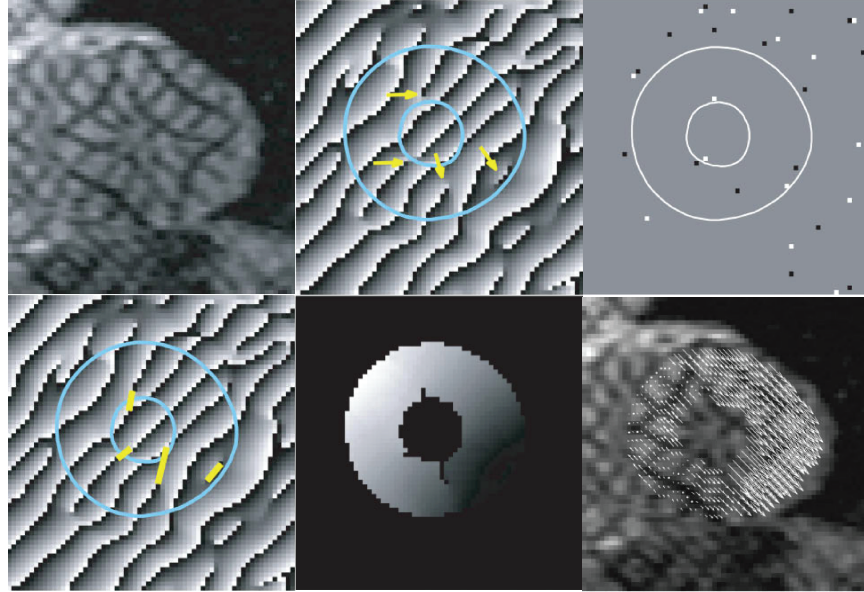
The procedure of phase unwrapping from a tagged MR image. Top left: raw tagged MR image of short-axis view. Top middle: corresponding HARP image with tag orientation of 45° as well as myocardial contours of left ventricle. Phase discontinuities (residues) are denoted with yellow arrows. Top right: positive (white) and negative (black) residues. Bottom left: branch cuts connecting positive and negative residues or residues and contours are shown in yellow. Only residues within the myocardium are resolved. Bottom middle: unwrapped phase with quality-guided phase unwrapping. Bottom right: computed 1D displacement along 45° orientation overlaid on the raw image.
